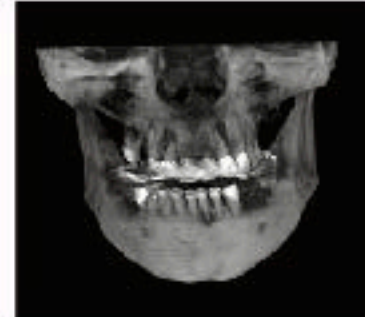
Three-dimensional imaging modalities, such as cone beam computed tomography (CBCT), are essential for proper diagnosis and treatment planning.
